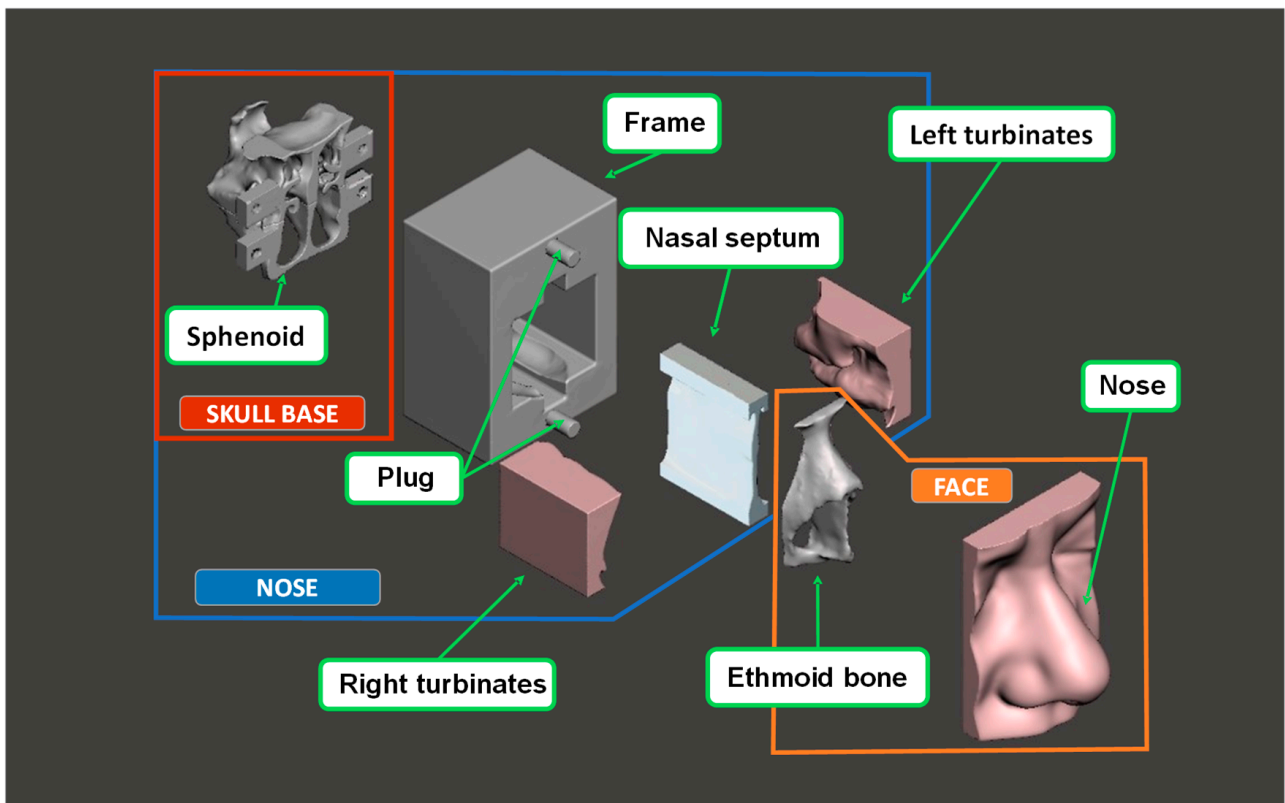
Exploded view of the CT-based training model with the modules highlighted.
